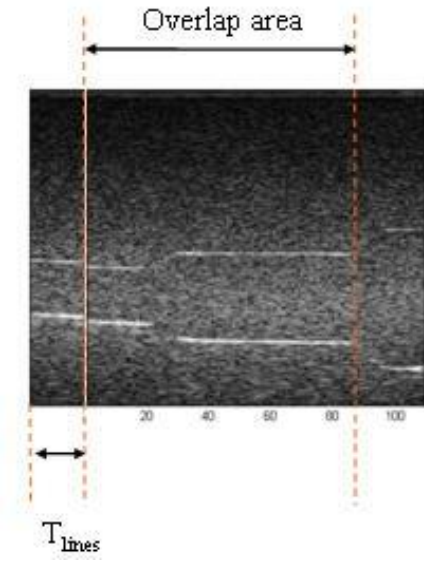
Bmode ultrasound data: translation T_{lines} and the length of the overlap area.
